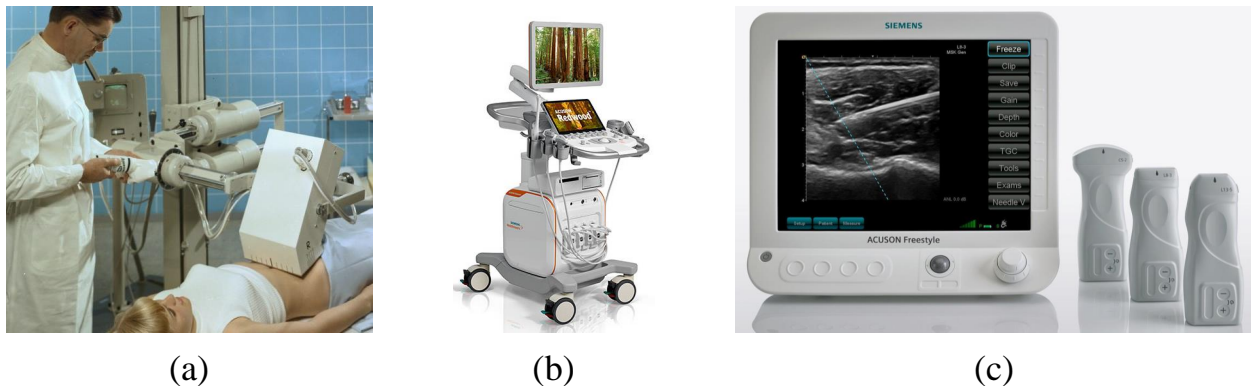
Three different generations of Siemens ultrasound machines. (a) Vidoson 635 [5]. (b) ACUSON Redwood [6]. (c) ACUSON Freestyle [7]. All images obtained from Siemens company website with permission.
